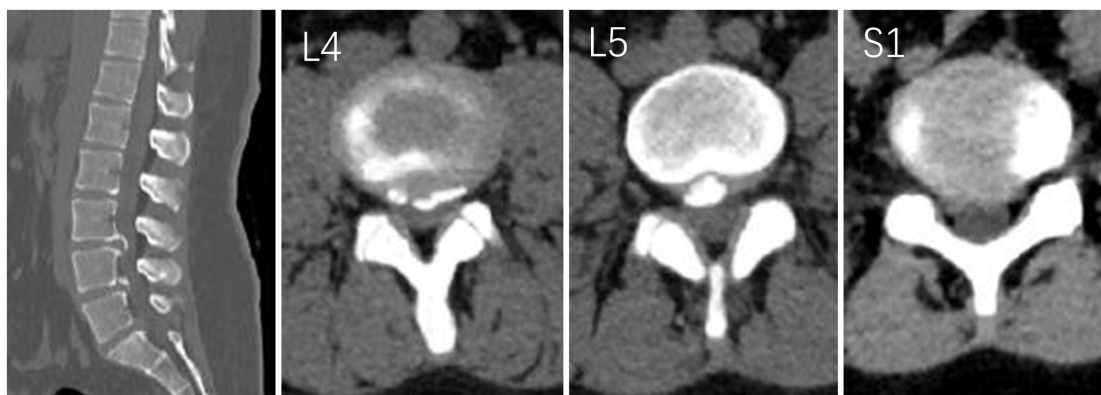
Preoperative lumbar spine CT showed L3/4 and L4/5 disc herniation with disc calcification, prolapsed disc at L5/S1, and spinal stenosis in the corresponding segments
